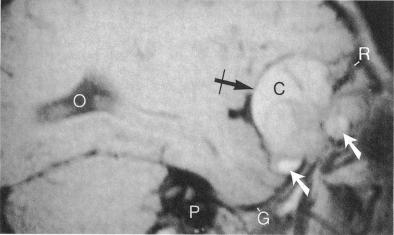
$T_I$ -weighted coronal (upper) and sagittal (lower) MRI show high signal from the blood filled cavities (white arrows). The central part of the lesion, presumably solid tumour, gives a lower signal on the sagittal image. The cyst (C) is extradural and has a well defined margin (crossed arrow). C=cyst. G=greater wing of sphenoid. L=left globe. O=occipital horn of lateral ventricle. P=petrous bone. R=orbital roof.
